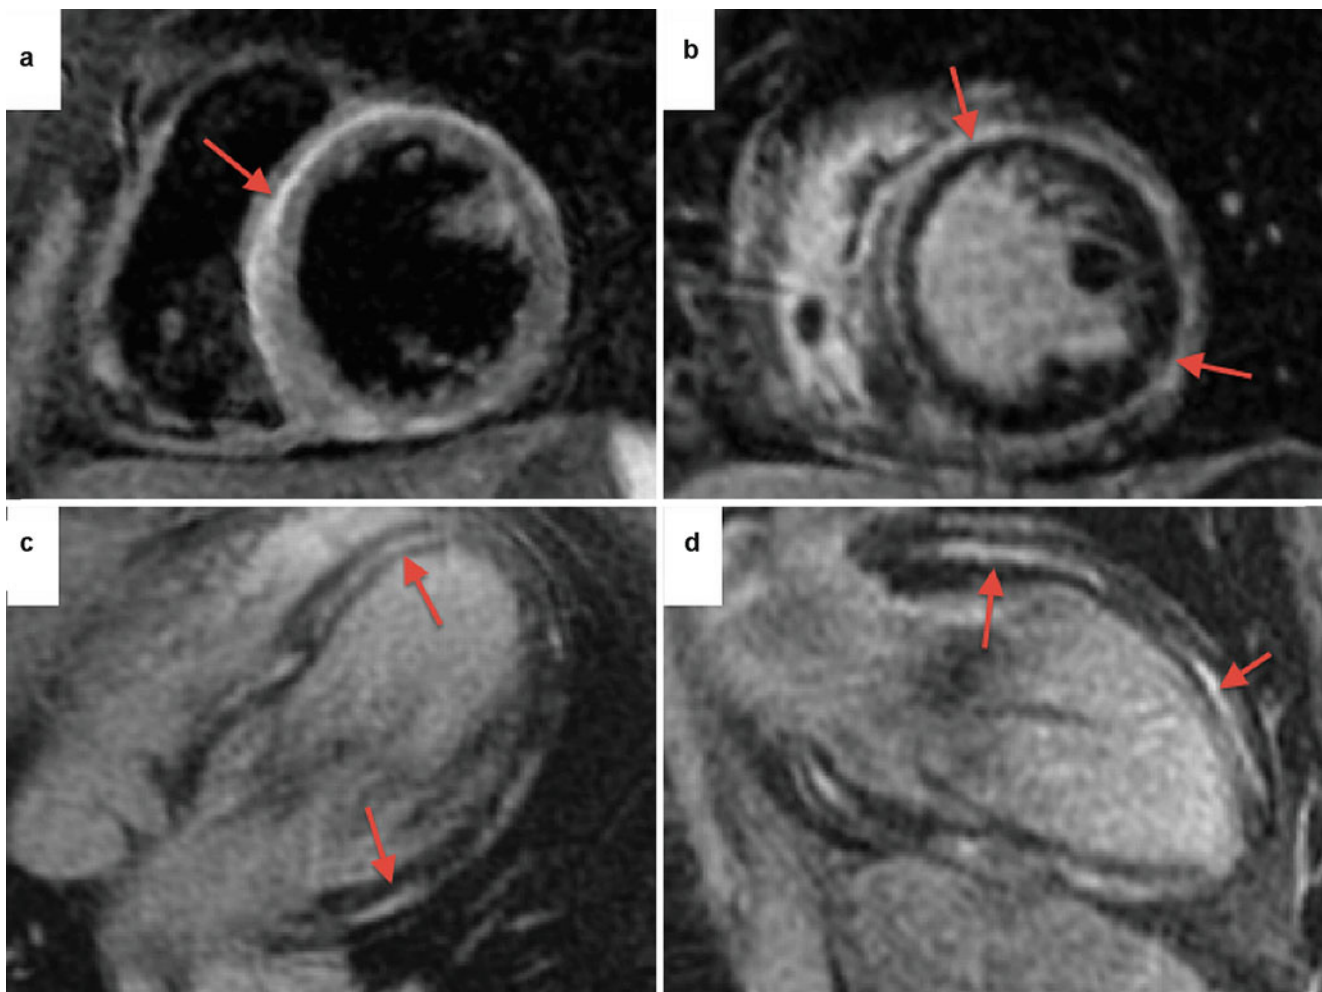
An 18-year-old female was admitted with severe chest pain and elevated serum troponin and normal coronary arteries by angiography. (a) Short-axis T2-weighted inversion recovery sequence showing near-circumferential signal increase consistent with myocardial edema (red arrows, a–d). (b) Short-axis delayed enhancement sequence at a
